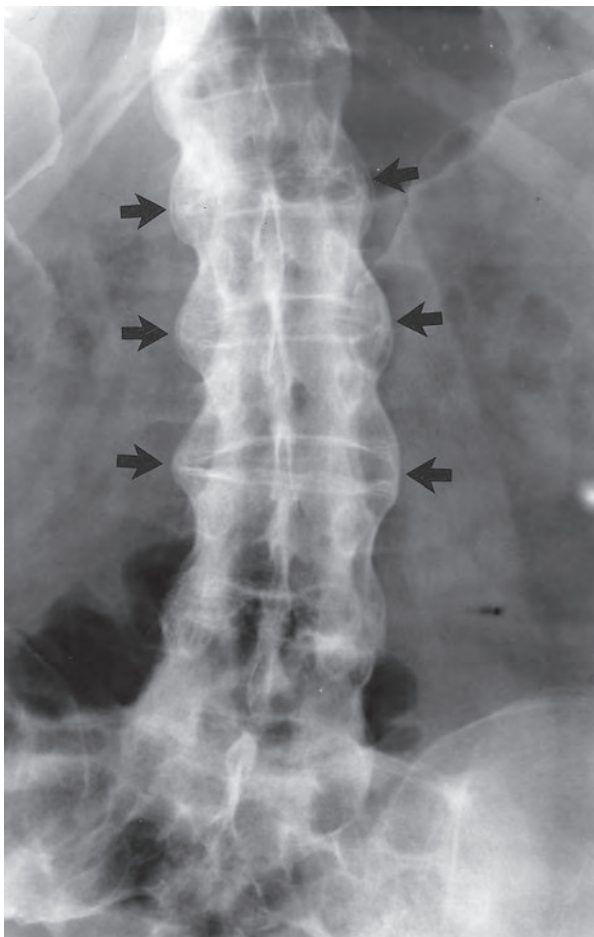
Ankylosing spondylitis. A frontal lumbar radiograph showing bone formation bridging the intervertebral disk spaces (arrows) and fusing the vertebrae.
